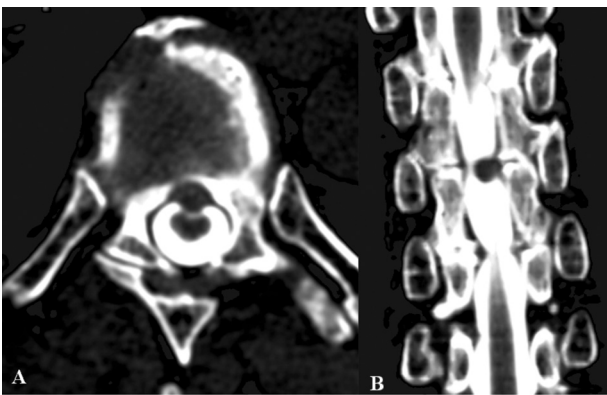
CT-assisted myelography: (A) axial view at Th₇₋₈ level; (B) sagittal reconstruction — degenerative stenosis at Th₇₋₈ level
